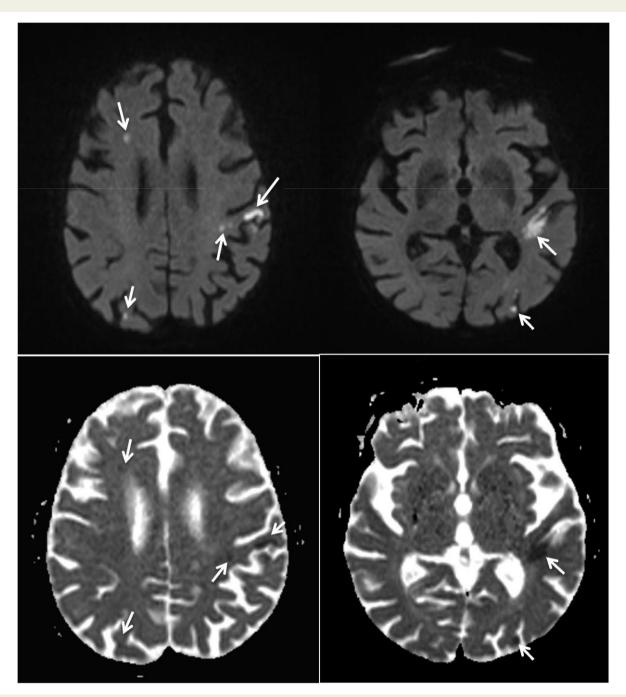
Diffusion-weighted magnetic resonance imaging (DWI) (above) and apparent diffusion coefficient (ADC) map (below) showing a multi-territory ischaemic stroke, suggesting an embolic aetiology.
